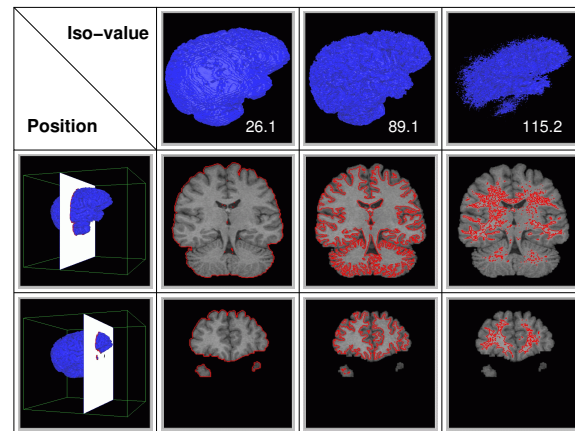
Matching of structures as seen in original 2D MRI slices and extracted isosurfaces.
